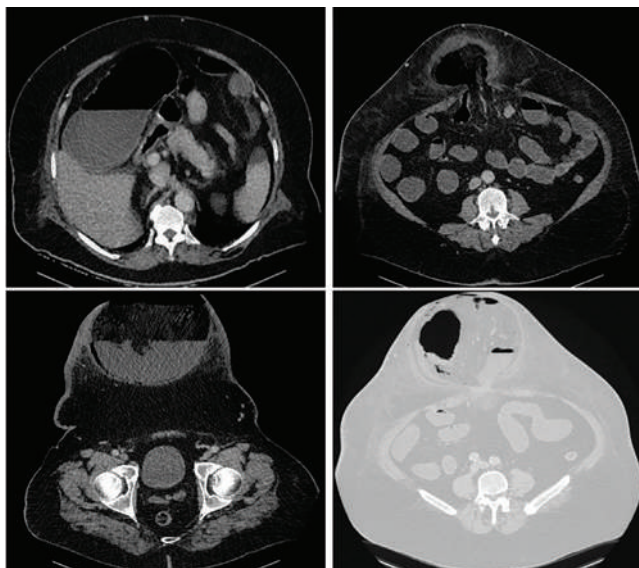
Computed Tomography (CT) images demonstrate herniation of the distal segments of the transverse colon through a defect at the level of the umbilicus, dilatation of the bowel loops proximal to the hernia sac with air-fluid levels, and the presence of free fluid and free air within the hernia sac.
